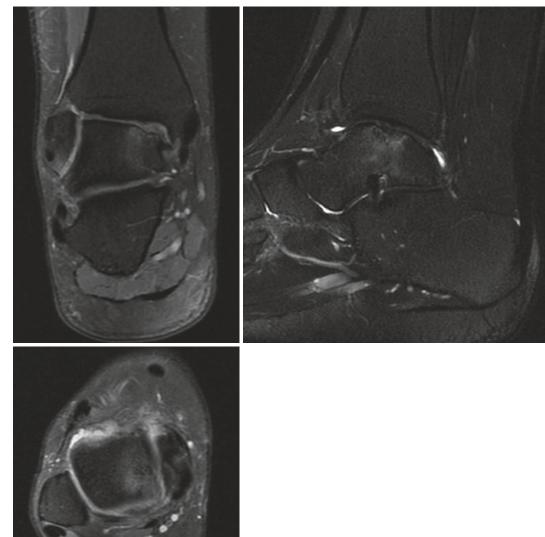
MRI of the same lesion in Fig. 1
